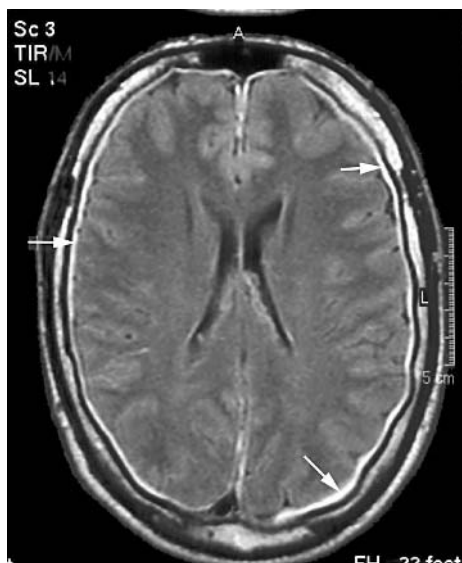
Cranial MRI (axial FLAIR sequence) also showing bilateral, small subdural haematomata (arrows).
